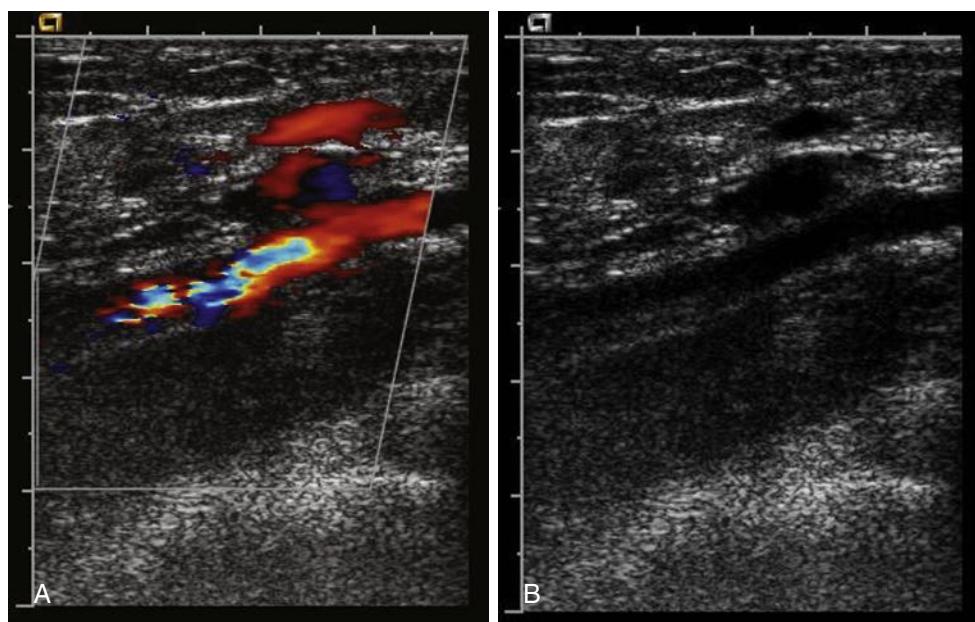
Brachial artery pseudoaneurysm after cardiac catheterization as seen through color duplex (A) and B-mode (B) ultrasound imaging.
